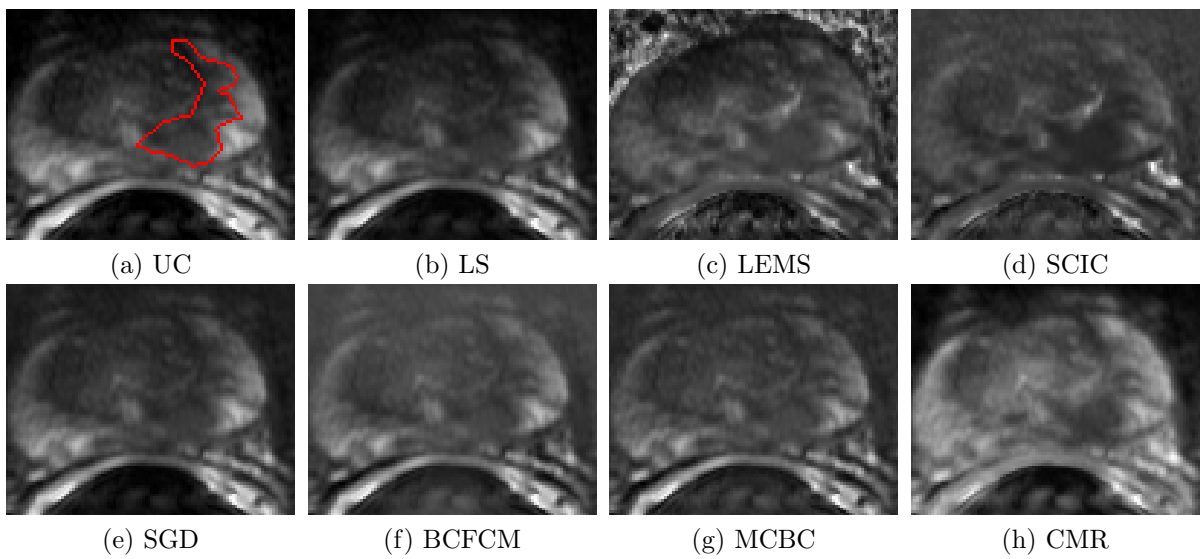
ADC images for a patient with tumor produced using different tested methods. The tumor location is marked using red contour in (a). Proposed CMR imaging reduces the bias field and noise in prostate DWI such that provides better representation of prostate tumor.
